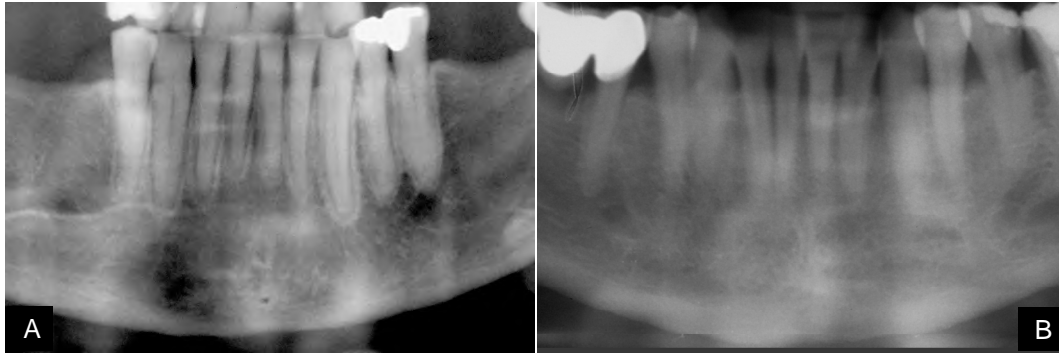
(A) Thickening of the lamina dura in a female patient under intravenous bisphosphonate therapy; (B) Radiographic aspect of lamina dura in a female patient under oral bisphosphonate therapy (Panoramic radiograph zoom)
